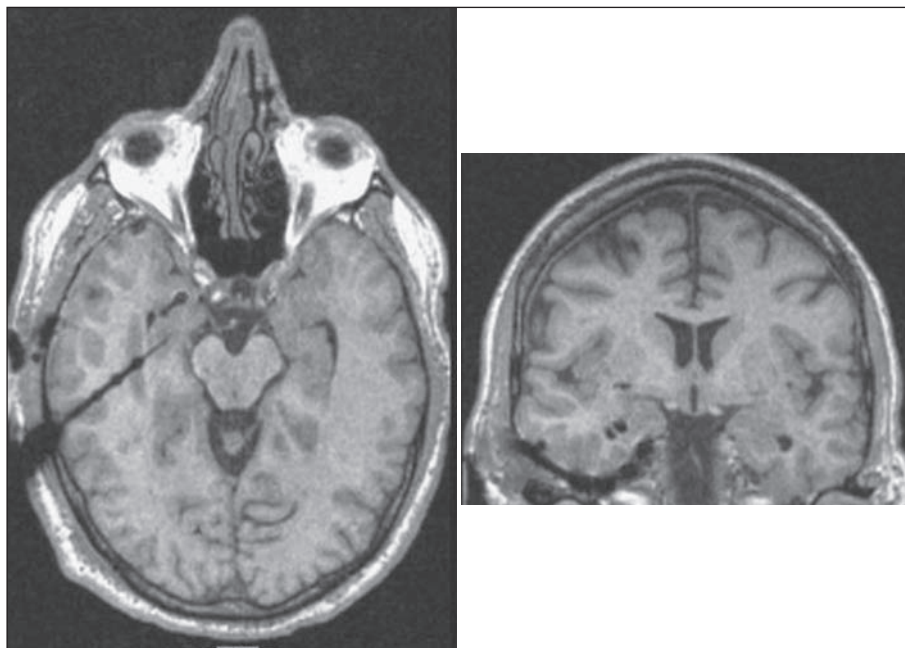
MRI showing the positions of depth electrodes targeting the right amygdala and hippocampus as well as the temporo-basal and temporo-lateral strips.
